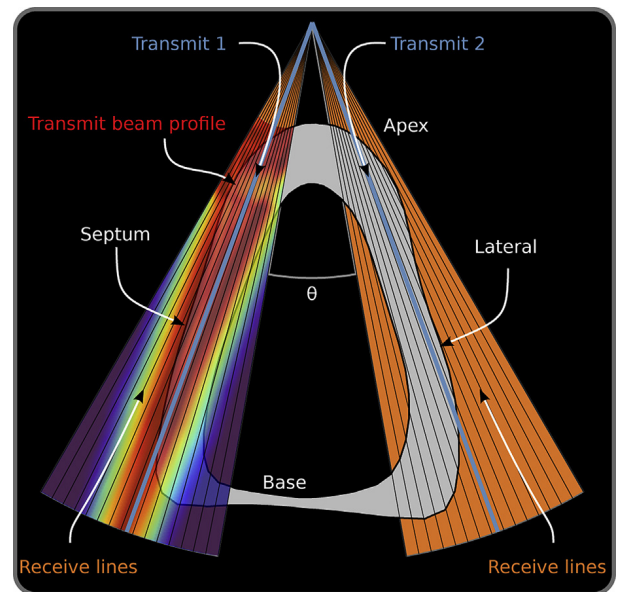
Transmit and receive directions for a scan setup of the left ventricle from an apical four-chamber view.
